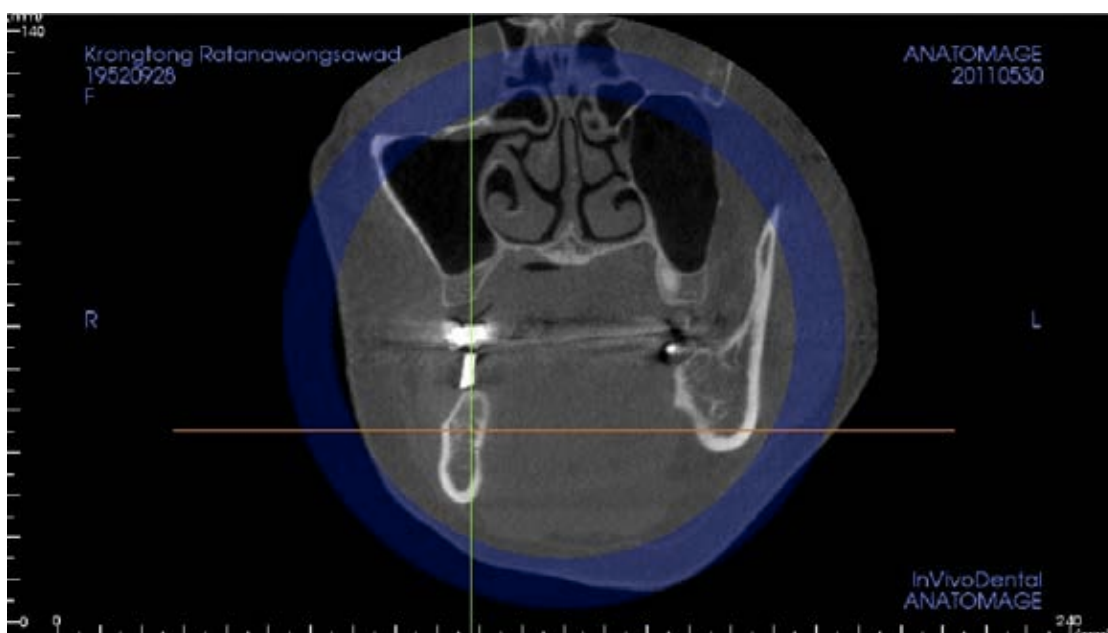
The center of planned implant in mandible, Cross-sectional CBCT view.
